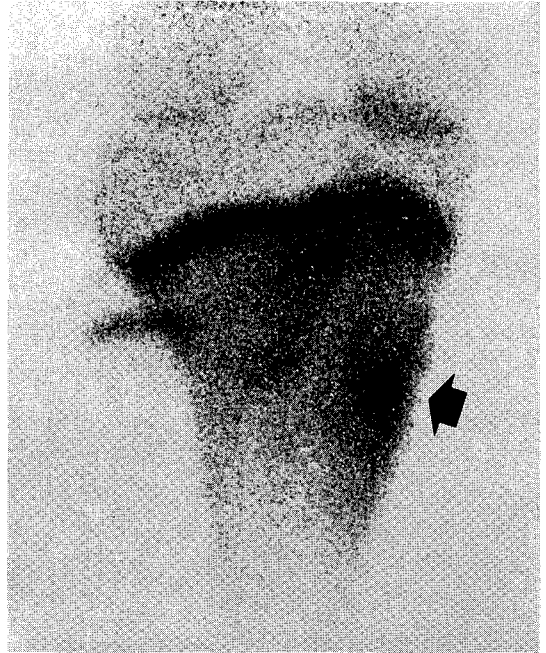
Pinhole bone scintigram of right proximal tibia showed discrete hotter spot within hot area (black arrows).
